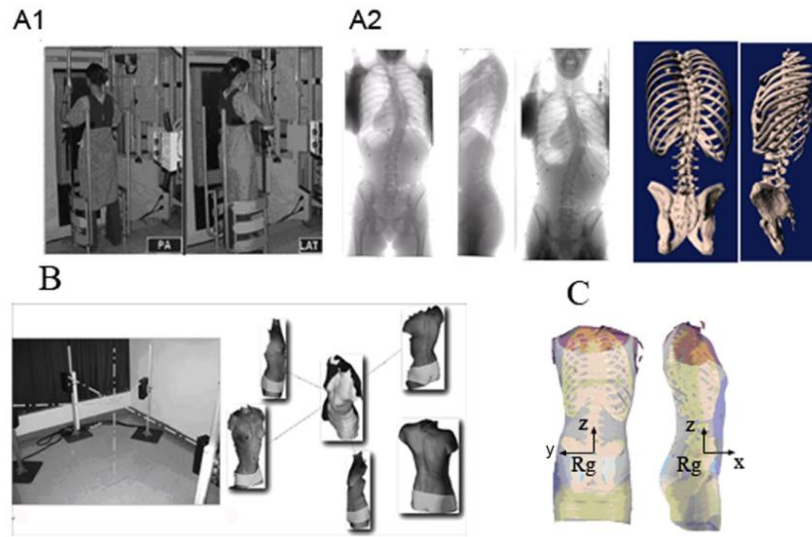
Article 5 Figure 1: A Acquisition of the internal geometry using the multi-view radiographic reconstruction technique: A1- PA and lateral acquisition; A2- PA, PA with an incidence of 20°, and lateral radiographs; A-3 3D reconstruction) ; B Acquisition of the external geometry using the range sensor topography technique; C Superimposition of the two geometries.
